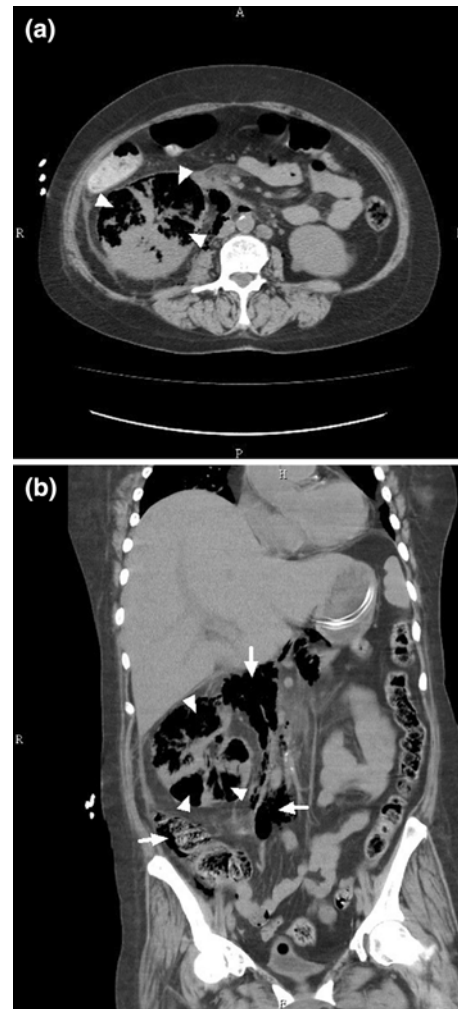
Transverse view (a) and coronal view (b) from contrast-enhanced computed tomography of a 56-year-old woman showing massive gas within (arrowheads) and around (arrows) the enlarged right kidney
